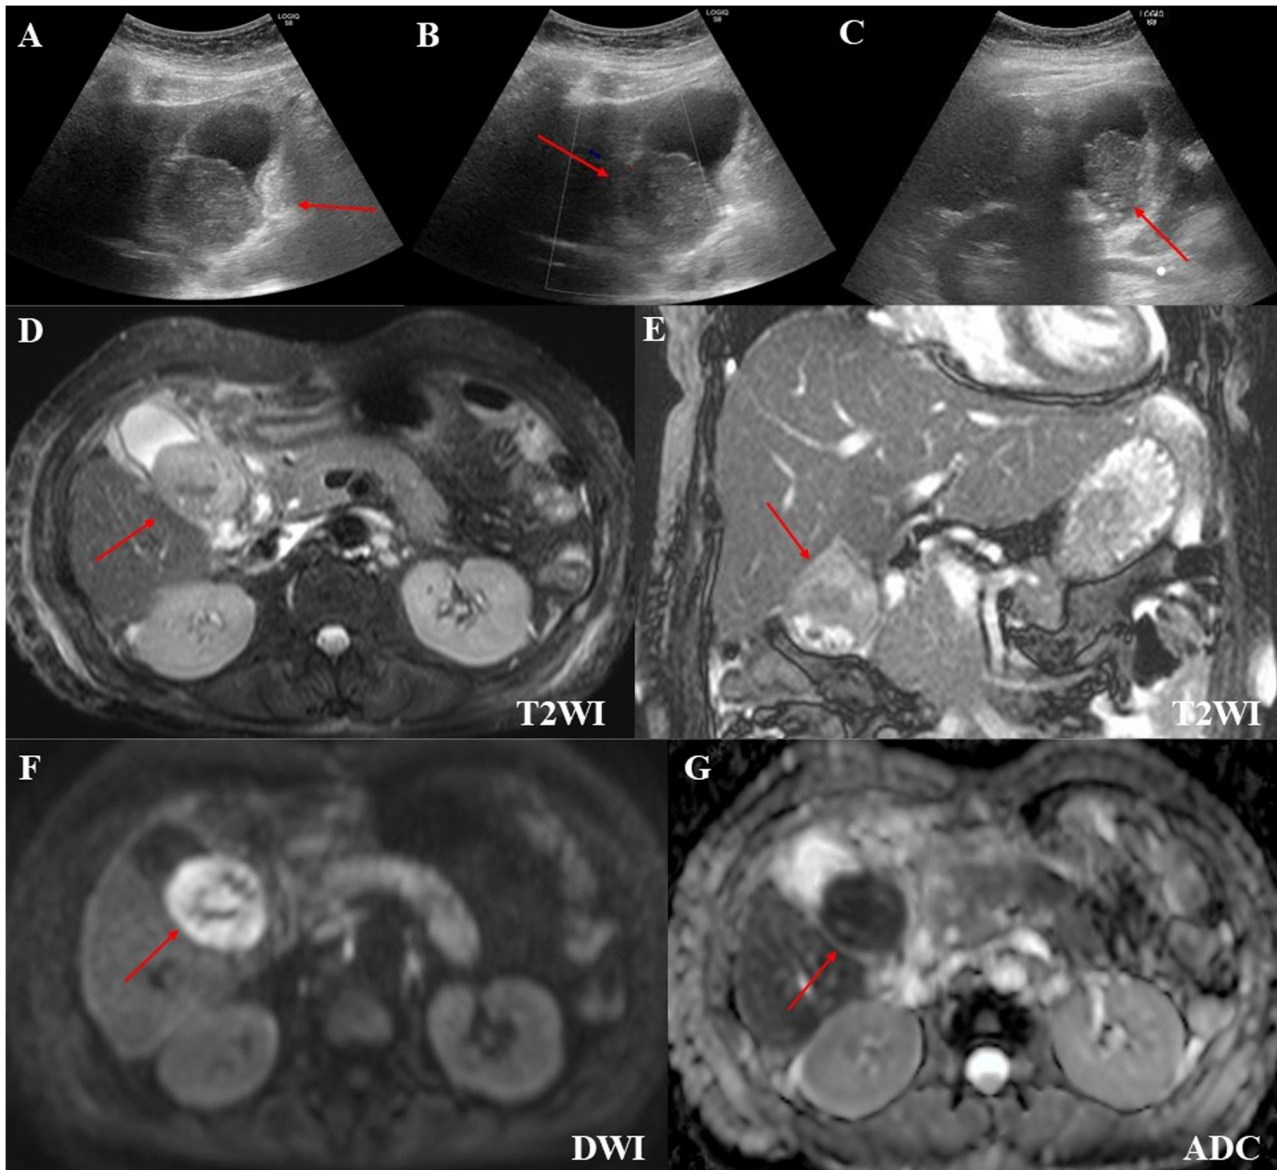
Gallbladder ultrasound findings and magnetic resonance imaging findings. Ultrasound showed a neoplastic lesion that was not deformed by body movement. (A) The arrow indicates thickening of the wall; however, the lamina structure was preserved. The mass (B) was hypoechoic and (C) had poor blood flow. (D) MRI showed a T2WI iso-low signal. (E) Multiple gallstones were observed. (F) DWI showed a high signal. (G) ADC map demonstrated a low value. DWI, diffusion-weighted imaging; ADC, apparent diffusion coefficient.
